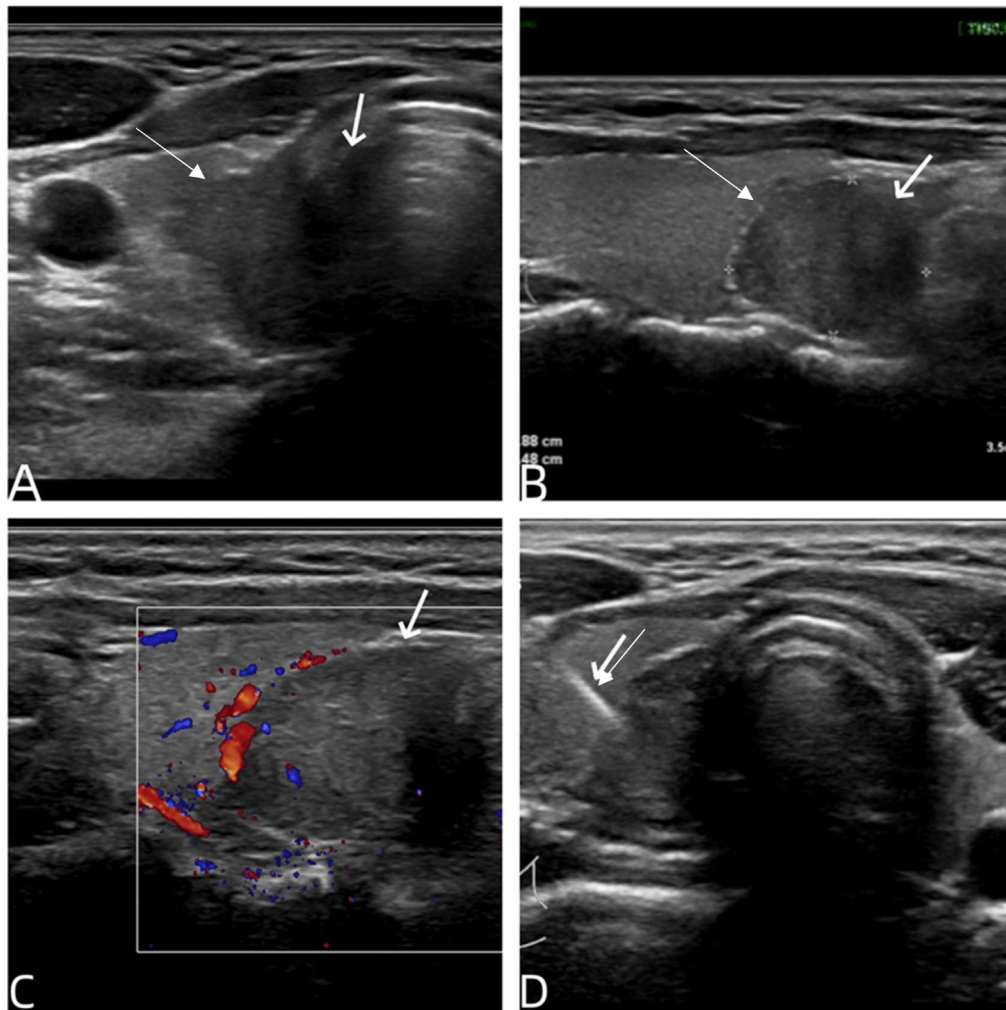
Ultrasonography. (A) there was a hypoechoic nodule (white arrow) in the right lobe of the thyroid, inseparable from trachea in the transverse section. (B) The nodule measured 1.9 × 1.5 cm and located in the lower part of the right lobe of thyroid in longitude section. There was a fine hyperechoic line between the nodule and the thyroid (white arrow). (C) There was peripheral strip blood flow and internal punctate blood flow in color Doppler flow imaging. (D) Ultrasound-guided fine needle aspiration biopsy. White arrow showed the needle.
